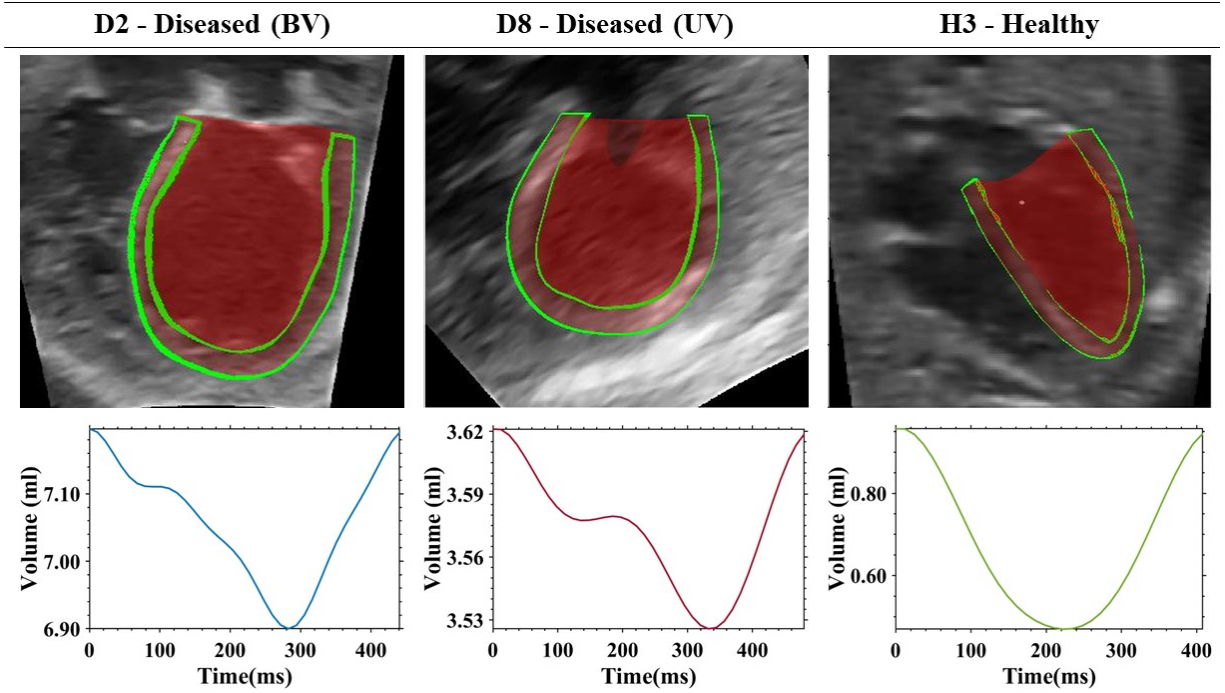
[Top row] Reconstructed geometries superimposed onto associated echocardiography image, green outline highlighting geometry proportion close to current image plane. [Bottom row] Volume over time variation of each geometry output from cardiac motion estimation methods.
